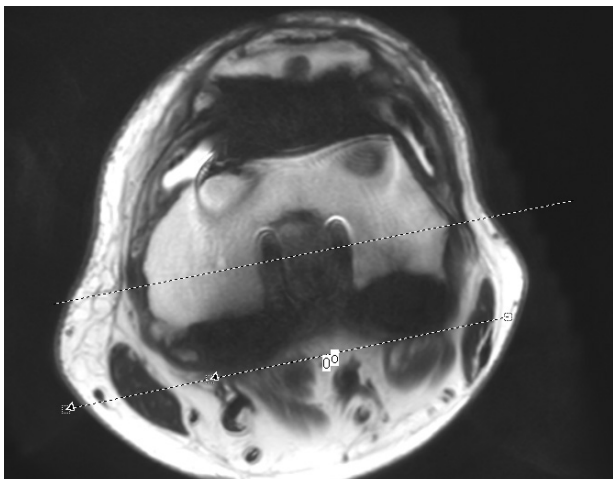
Axial MRI image of the distal femur showing a femoral component that is parallel to the surgical epicondylar axis (between the lateral epicondylar prominence and the medial sulcus of the medial epicondyle).
